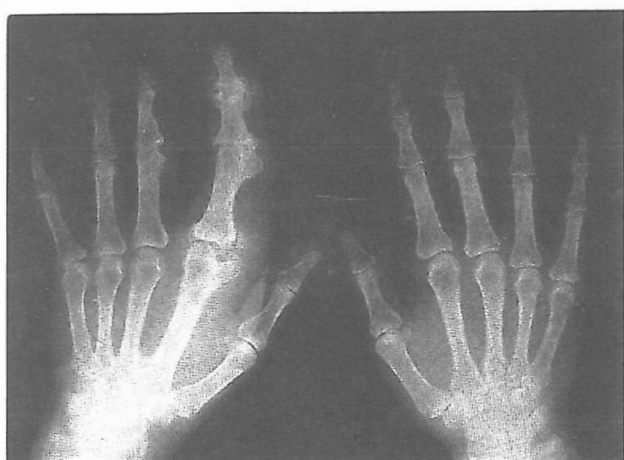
Radiograph of hands show soft tissue swelling and mottled lucencies around the index and middle fingers. Exostosis-like projections and secondary DJD changes in IP joints are also noted.
